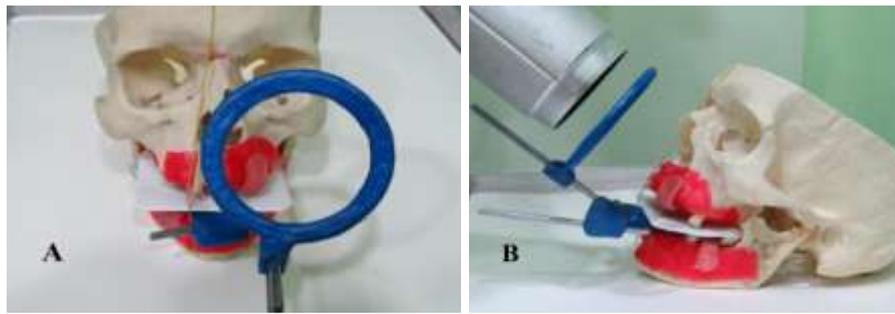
Assessment the accuracy of the horizontal (A) and vertical (B) angulations of the X-ray beam on the dry skull.
